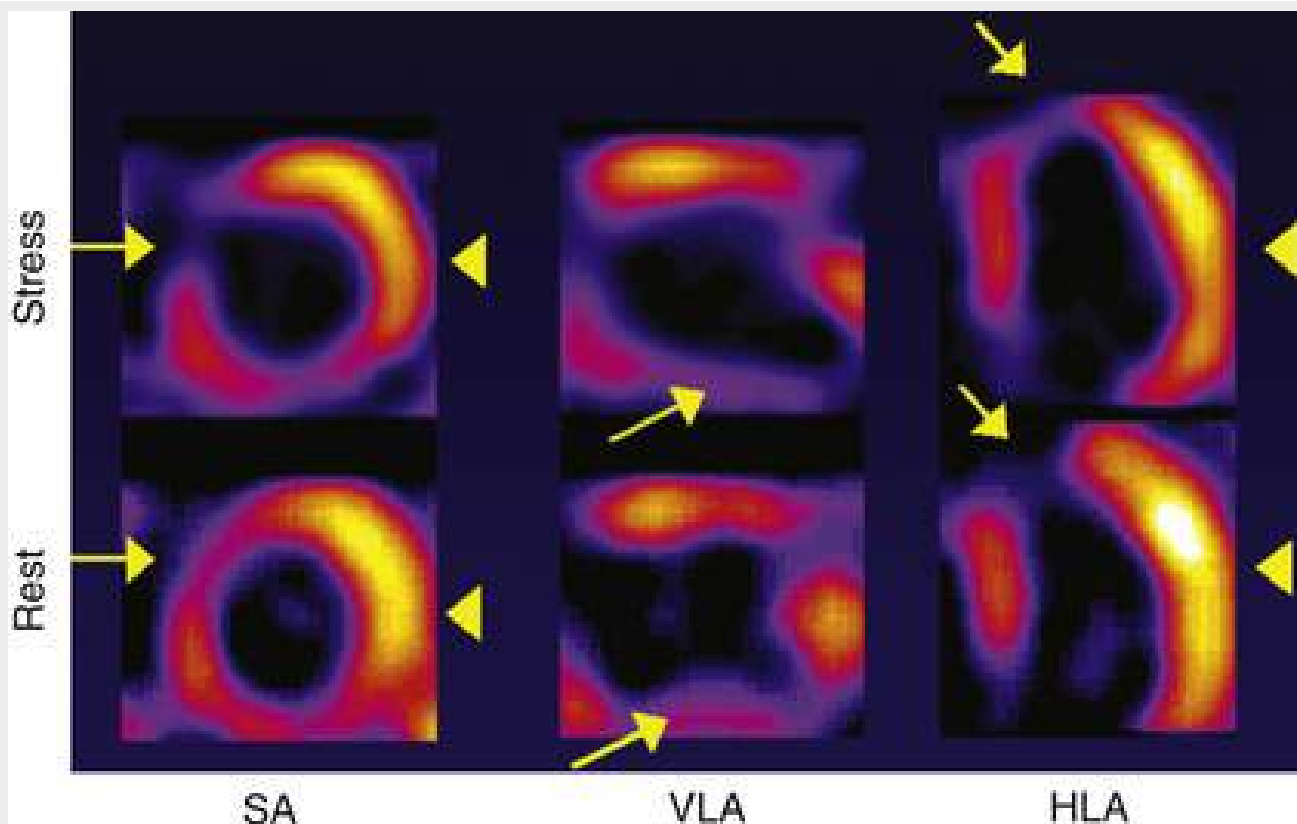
SPECT perfusion image demonstrating extensive severe fixed defects of the septum, apex, and inferior wall (*arrows*) suggestive of extensive previous myocardial infarction, as well as extensive inducible ischemia of the lateral wall (*arrowheads*). This set of findings strongly suggests that CAD is the cause of the heart failure syndrome observed in this patient. *HLA*, Horizontal long axis; *SA*, short axis; *VLA*, vertical long axis.
